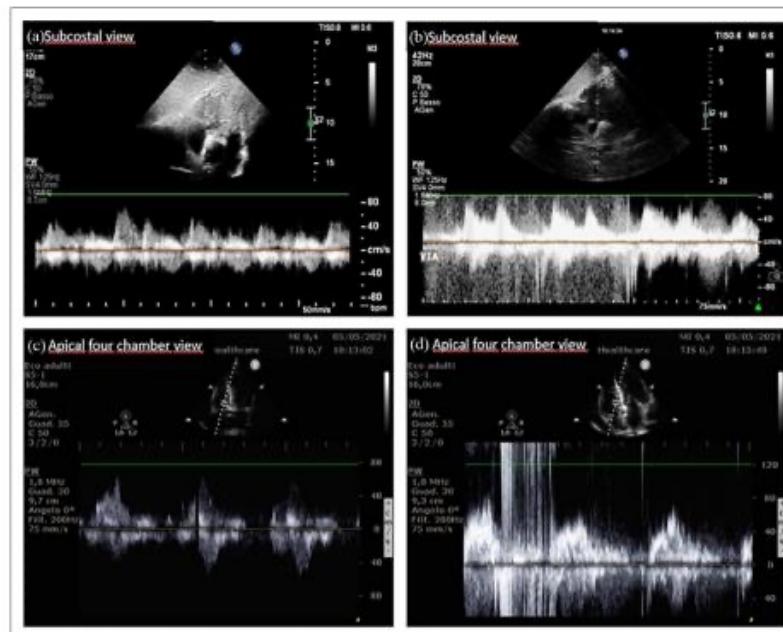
Example of MBT with pulse Doppler: (a) subcostal view; tricuspidal Pulse Doppler before microbubble injection, (b) subcostal view; tricuspidal Pulse Doppler during microbubble injection: MES appear immediately after the injection, (c) apical four chamber view; tricuspidal Pulse Doppler before microbubble injection, and (d) apical four chamber view; tricuspidal Pulse Doppler during microbubble injection: MES appear immediately after the injection.
